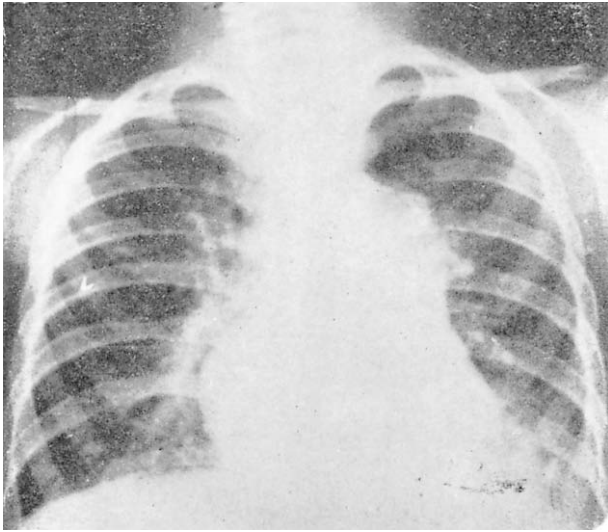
Chest radiograph of a 4-year-old Han boy with high-altitude heart disease. He was born at 3400 m. There is marked prominence of central pulmonary artery branches and enlargement of the right atrium and right ventricle. Data from Lin et al.¹⁴
